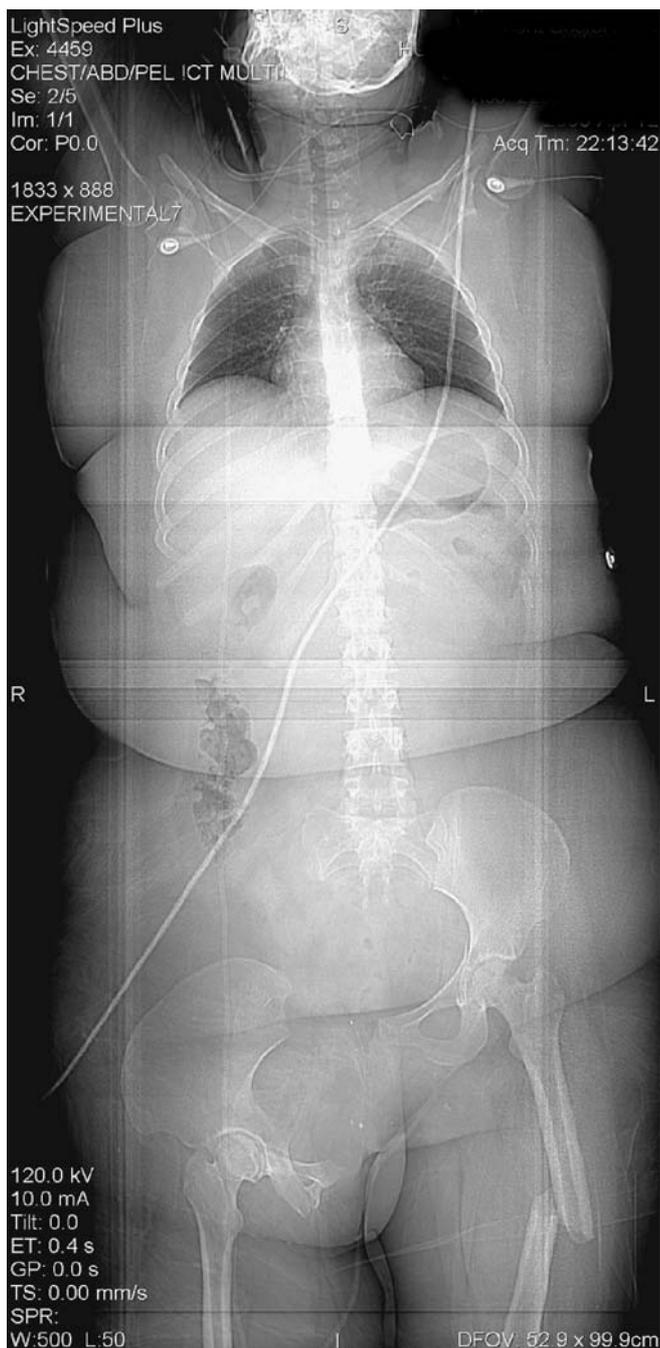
Scout image from initial CT scan demonstrating grossly displaced right hemipelvis, as well as left acetabular and femur fractures. Also note significant patient obesity
